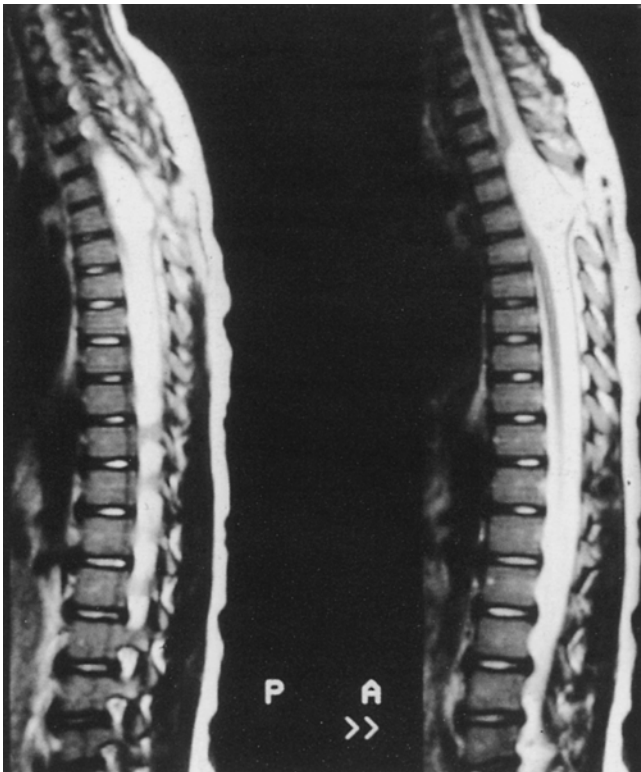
Sagittal T2-weighted MRI of the spine showing a large dermoid (giving the same signal as fat) with marked compression of the spinal cord
